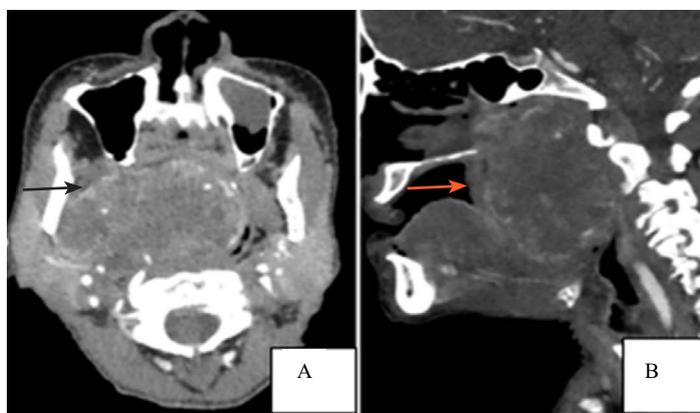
CT scan of the neck (A) axial and (B) sagittal views. A – well circumscribed heterogeneously enhancing mass (thin black arrow) in the right parapharyngeal space at the level of the nasopharynx crossing the midline and compressing the airway; B – thin orange arrow shows posterior extension to the prevertebral space and posterior tongue depression.
